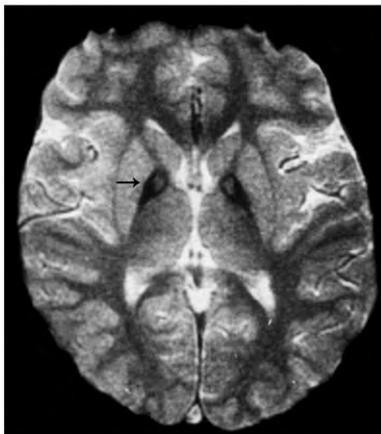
Brain MRI of subject with pantothenate kinase-2 associated neurodegeneration (PKAN). T2*-weighted echo-planar sequence demonstrates characteristic “eye-of-the-tiger” sign in the globus pallidus (arrow). Modified from [105], with permission.
